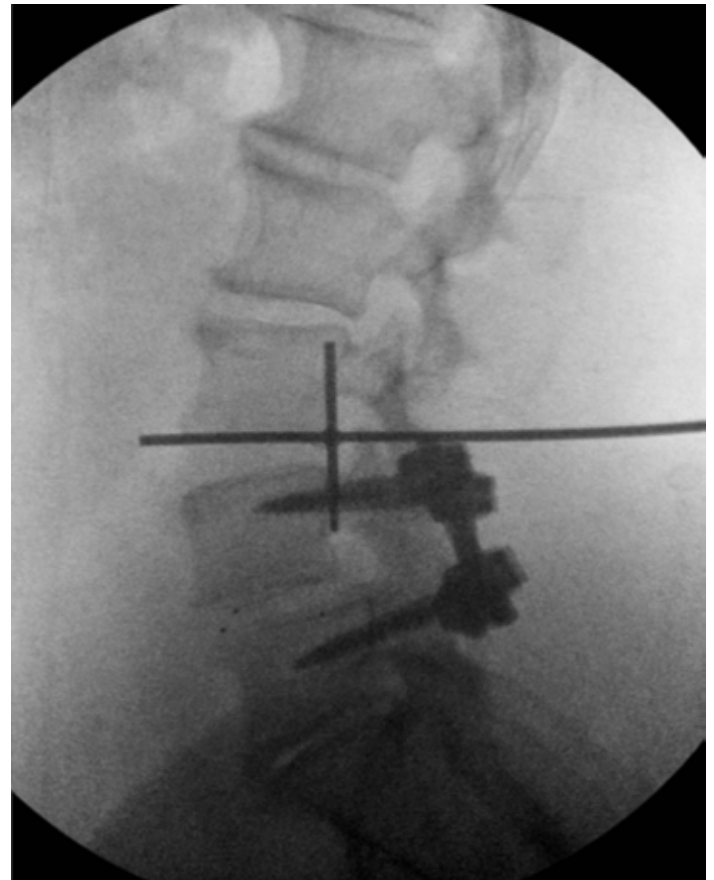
C-arm positioning is demonstrated for an AP radiograph.
